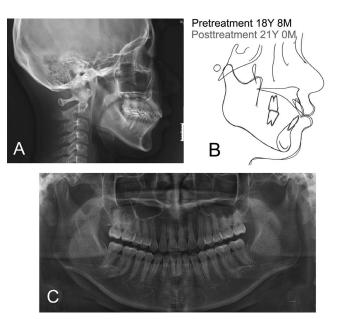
Posttreatment radiographs and superimposition.
